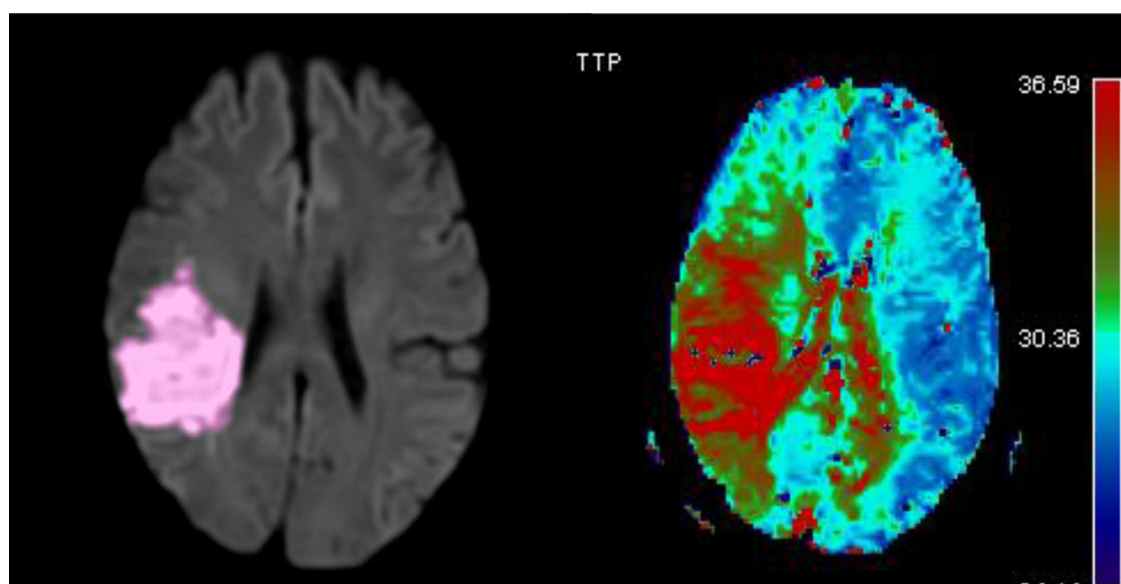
MRI perfusion-diffusion mismatch. The small lesion on diffusion-weighted imaging (DWI) represents the infarct core, while the much larger area in the time to peak map calculated from perfusion imaging (PWI) identifies the area of critically hypoperfused tissue (prolonged TTP).
